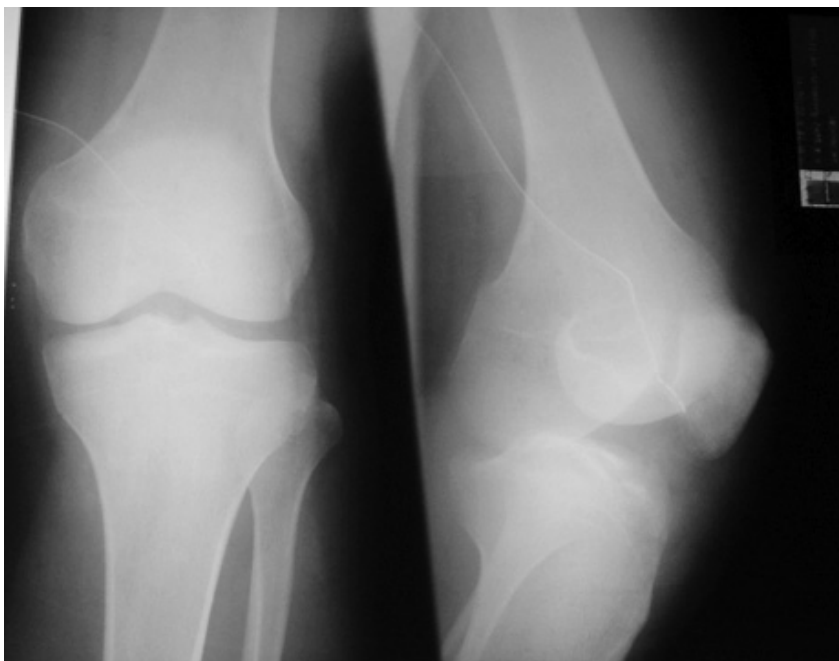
(a, b) Post-operative x-ray showed no tibial plateau fracture of right knee.
